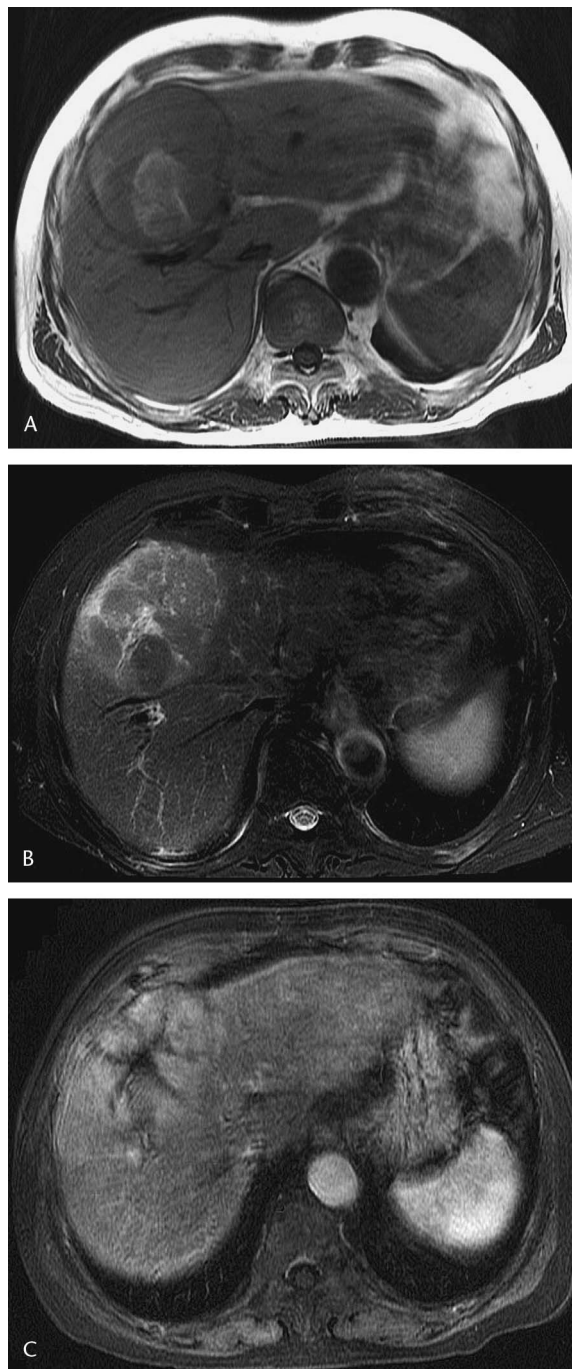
FNH. A, Unenhanced T1-weighted image demonstrates a smoothly margined isointense tumor with a hyperintense portion. B, Fat saturation T2-weighted image reveals slightly hyperintense tumor with a central scar and its intensely bright signal. C, Enhanced T1-weighted image shows a homogeneous enhanced tumor with hypointense central scar.
